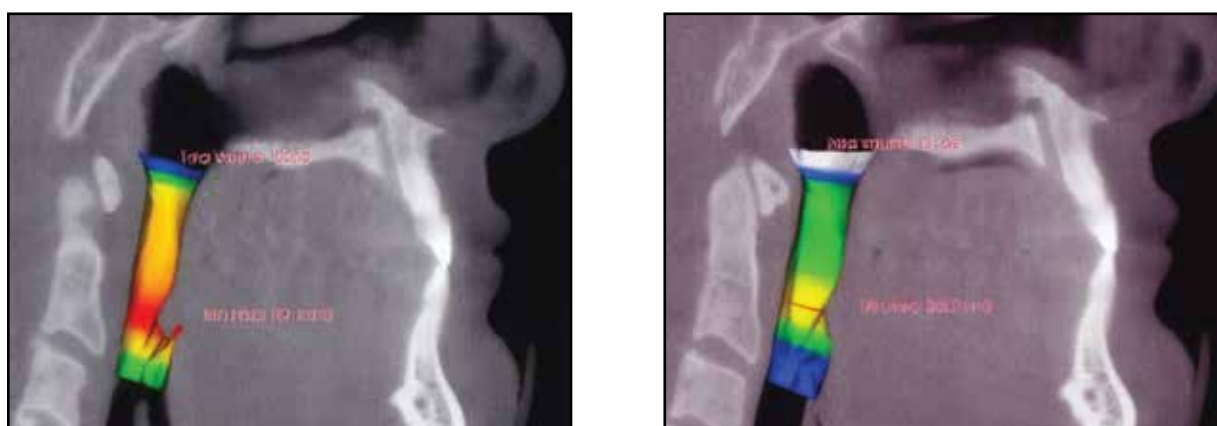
Airway volume a) Before and b) After. Volumetric assessment of patient's airway using sagittal cone beam computed tomography image and anatomege's Tx Studio software before and after non-ablative laser treatment. Note the increase in both total volume and area of minimum constriction after laser treatment.
